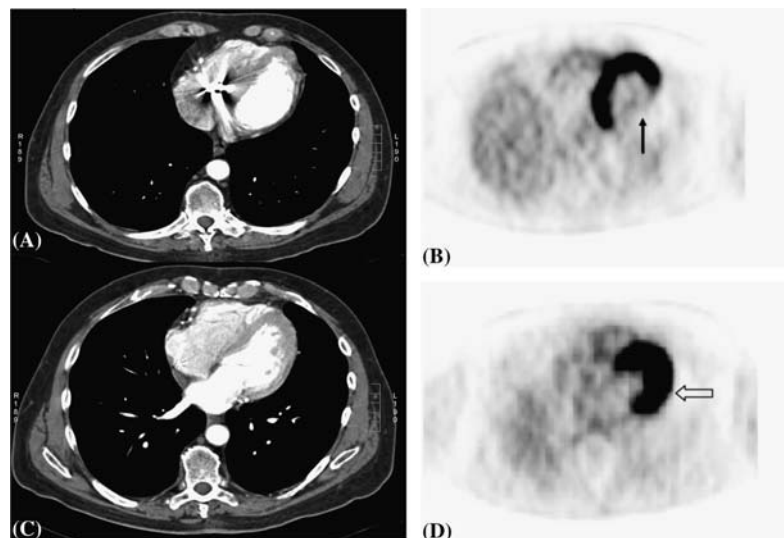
Contrast enhanced axial CT scan shows hypoenhancement with thinning of the mid to basal inferolateral myocardium (A). F-18 FDG PET scan shows a corresponding metabolic defect indicating presence of old infarction or scar (B, solid arrow). However, in the basal anterolateral region, there is hypoenhancement without significant thinning (C). The basal anterolateral region demonstrates FDG uptake indicating presence of viable hibernating myocardium (D, open arrow).
